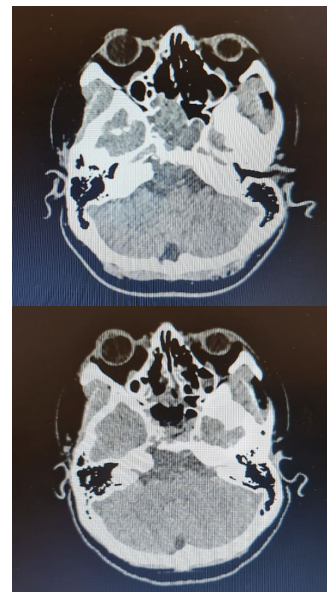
Image of chordoma size on pre- and post-operative non-contrast CT scans, showing a reduction in size on case 1
